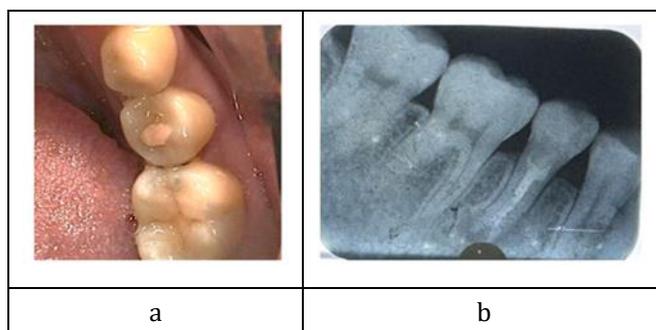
Initial photograph (a) clinical. (b) periapical radiograph
